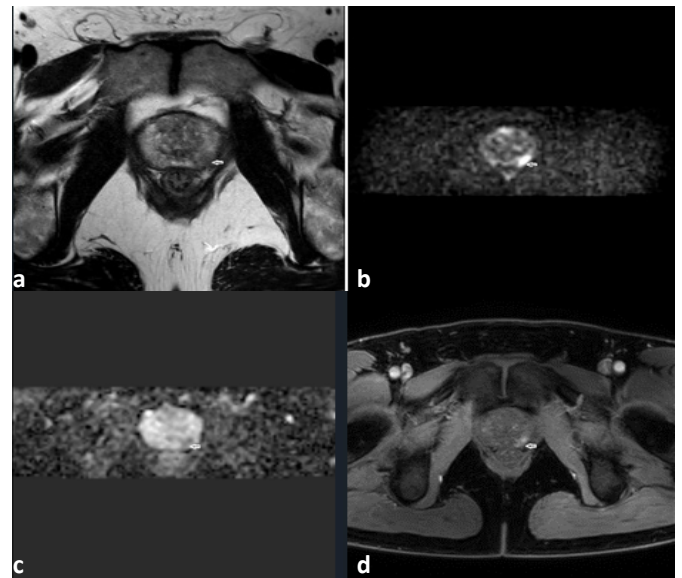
55-year-old patient with PSA 5.63 ng/ml, left peripheral zone hypointense area on T2 (a), hyperintense on DWI (b), hypointense on ADC (c), early arterial phase contrast enhancement in dynamic contrast images (d) PIRADS 4 lesion. Fusion biopsy result was compatible with Gleason score 4+3
